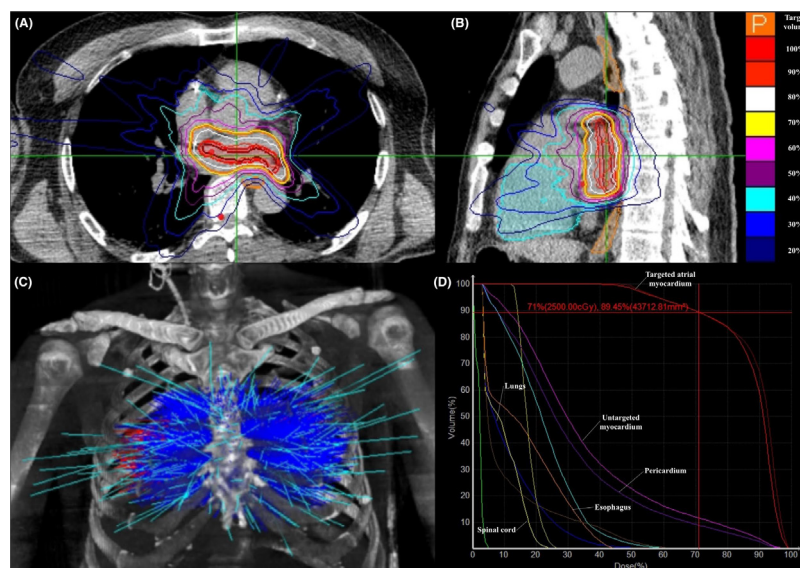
Planning and delivering stereotactic radioablation to the LA (patient 1): panels A and B show transverse and sagittal CT images through the LA demonstrating radioablative isodose contours within and around the planned treatment volume defined by the orange line. Panel C demonstrates the calculated multiple beam angles used to deliver a conformal dose distribution to the treatment volume. Panel D shows the proportion of dose delivered to the targeted atrial myocardium and other nearby visceral tissue volumes; it can be seen that approximately 89% of the target volume received at least 25 Gy [30].
